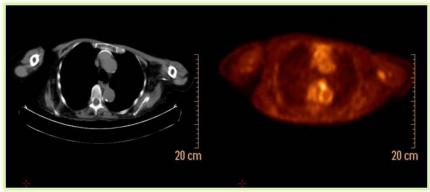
FDG-PET image, with abnormal hypermetabolism in thoracic aorta.
